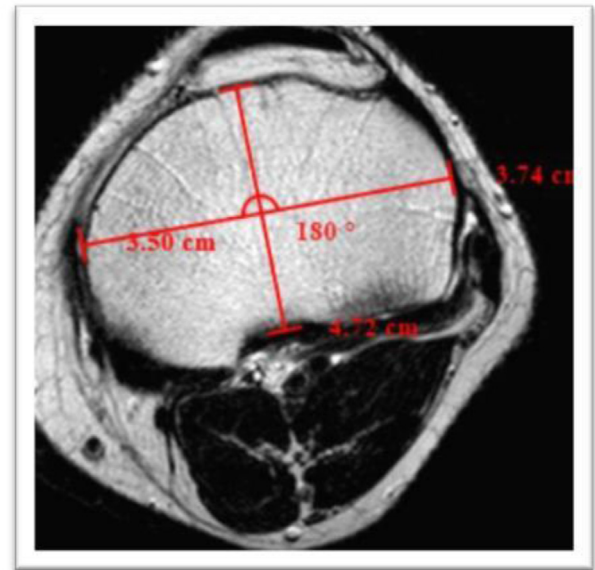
T2 weighted magnetic resonance image at the level of tibial cut, showing A-P and M-L dimension of tibia.
